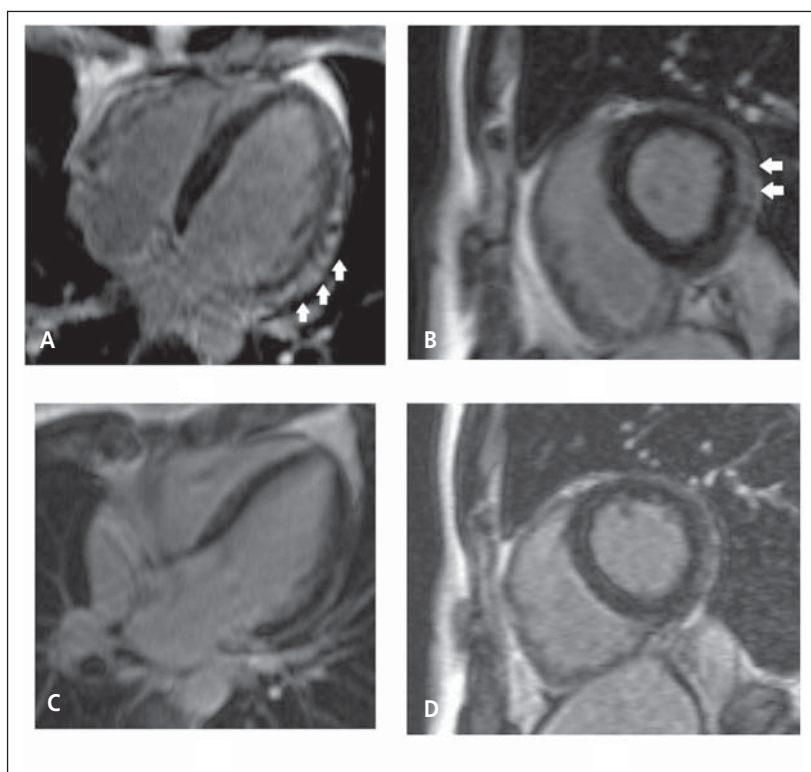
MRI – subepicardial localization LGE in one patient at hospitalization: (A) long axis, (B) short axis and decrease LGE load at the 1 month follow-up, (C) long axis, (D) short axis.
